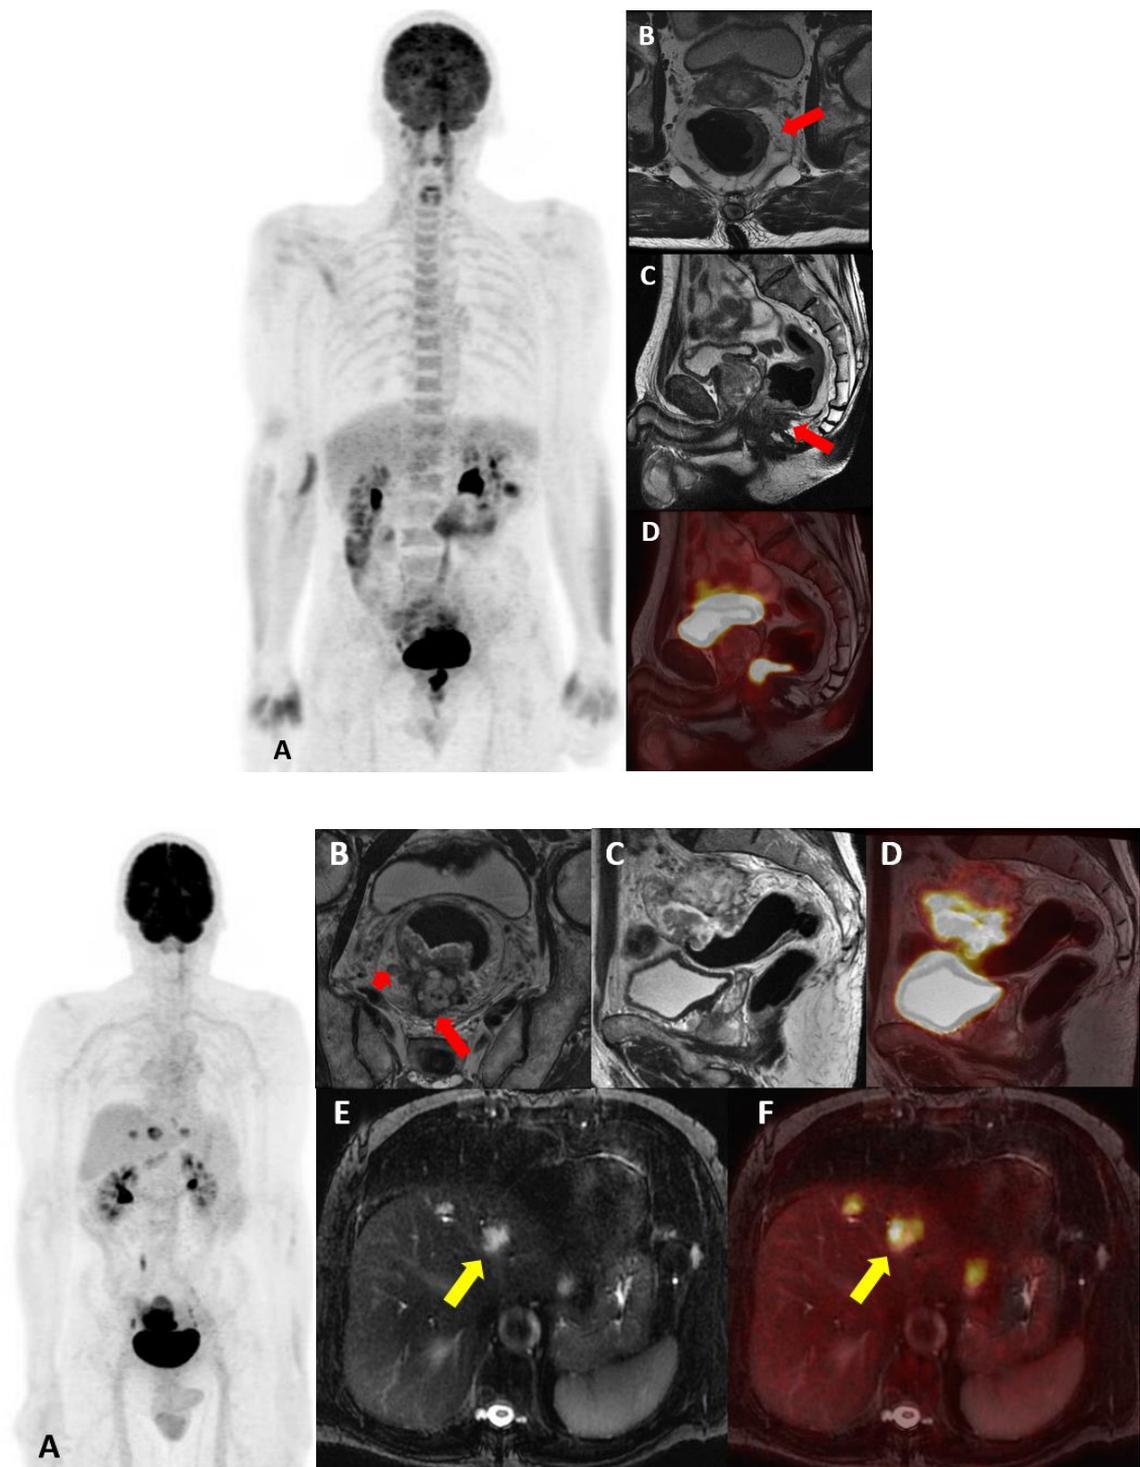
Two patients with high FDG uptake, one non-metastatic (Fig. 2a) and the other metastatic (Fig. 2b). Fig. 3a. Seventy-four-year-old man with low-risk rectal adenocarcinoma. Coronal MIP PET (A), axial T2w (B), sagittal T2w (C), and fused PET/MR (D). Although the SUVmax was 25.1, the primary tumor (red arrows)
